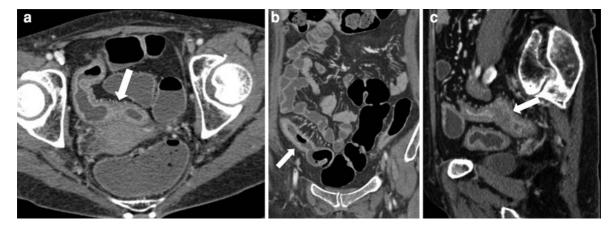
Contrast-enhanced axial (a), coronal (b) and sagittal (c) CT image showing mural thickening of ileum (*arrow*) with submucosal edema and mesenteric hypervascularity ("comb sign") indicated active disease
